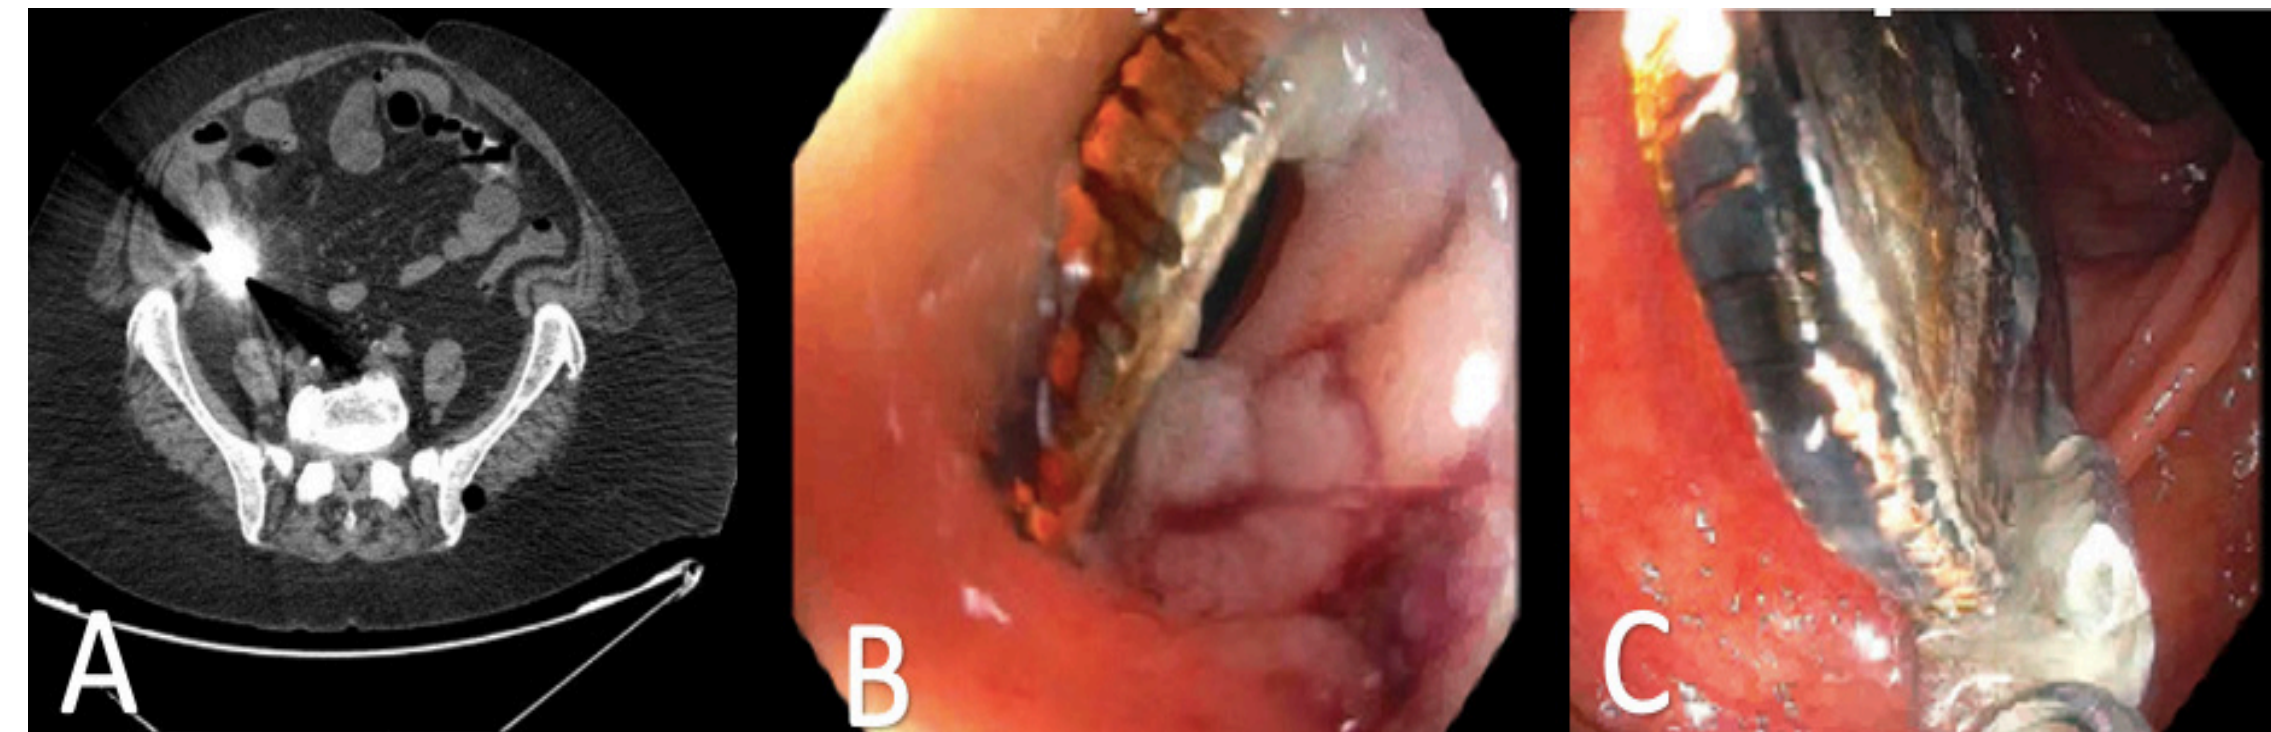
CT scan showing coin-like opacity in the terminal ileum.
